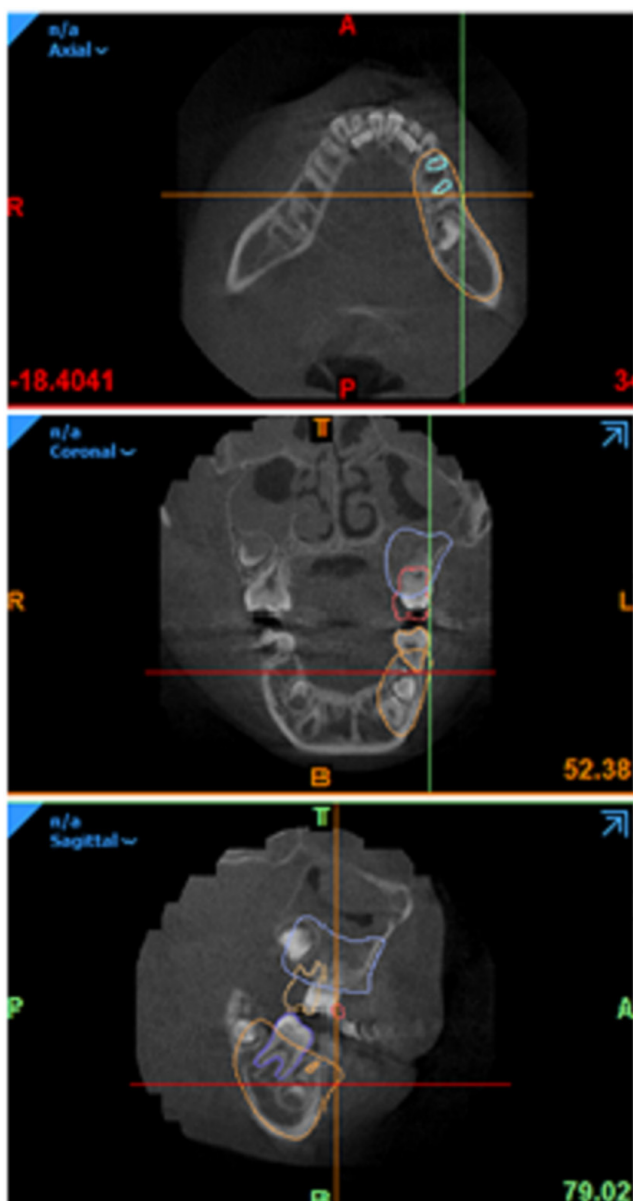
Cone-beam computed tomography (CBCT) images of a 6-year-old child's dentition
